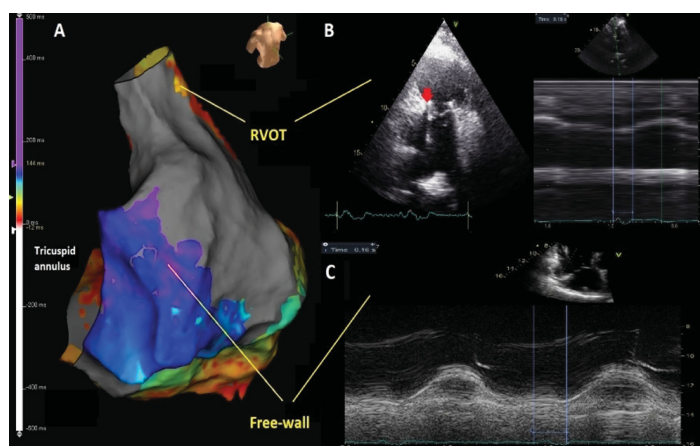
EAM and echocardiographic measures
